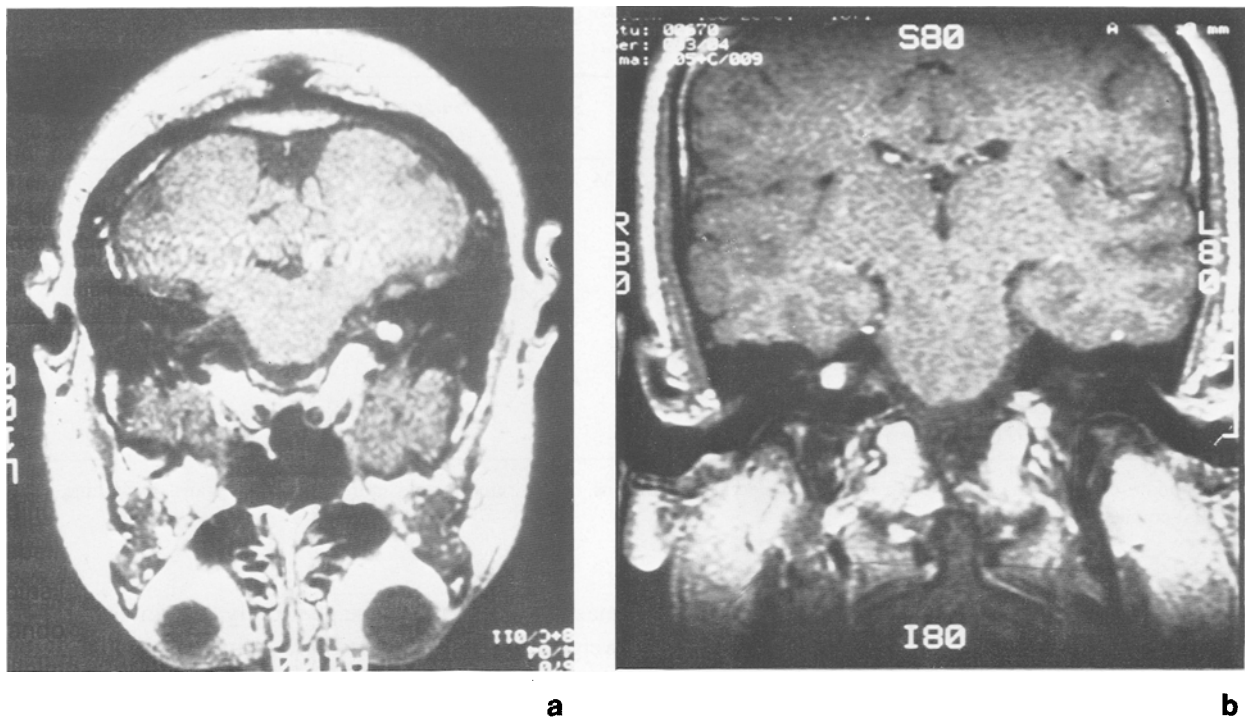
MRI with Gadolinium showing contrast enhancing lesion in the right internal auditory canal in axial image (a); as well as in coronal image (b)
